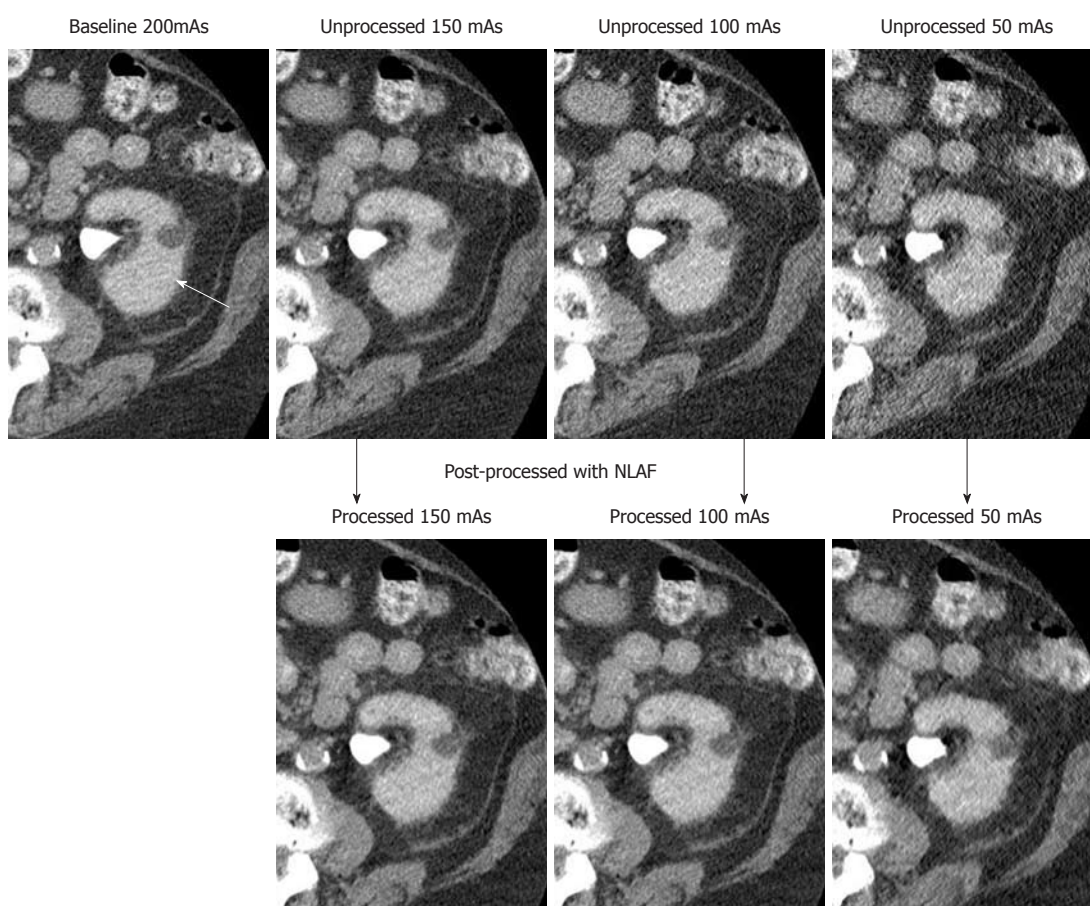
Transverse abdominal computed tomography images in a 72-year-old woman who underwent radiofrequency ablation for renal cell carcinoma showing a renal cyst (white arrow) in the left kidney at four different tube current-time product levels (200, 150, 100 and 50 mAs). Three lower tube current-time products (150, 100 and 50 mAs) when processed with 2D-non-linear adaptive filters showed lower image noise without affecting image contrast.
